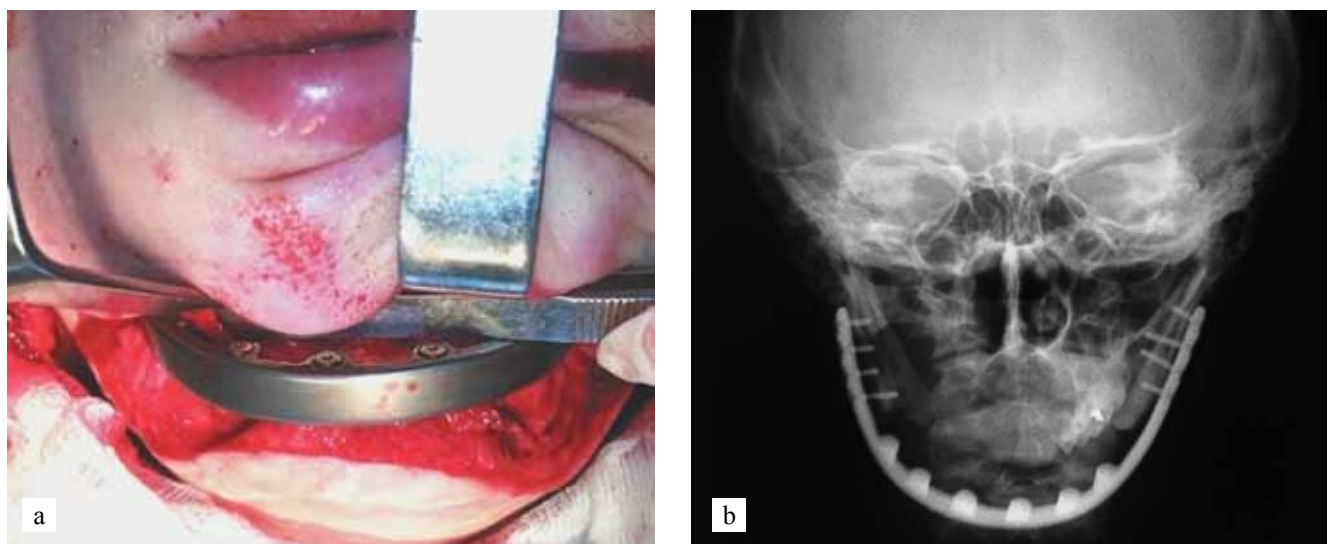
Implantation and fixation of the endoprosthesis: a – stage of the surgery; b – postoperative roentgenogram
